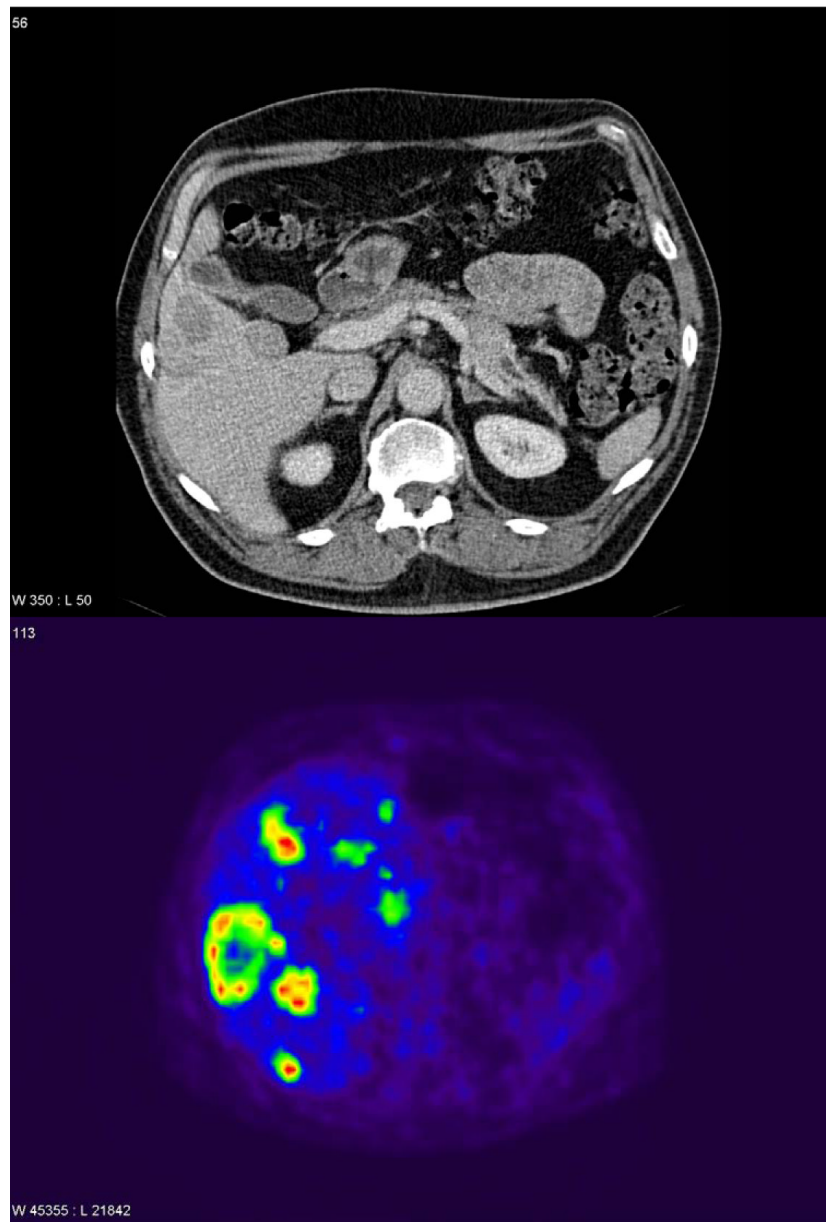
Comparison of the extent of liver metastases in a patient with a malignant PET on CT scanning (top panel) and positron emission tomographic scanning (bottom panel). This patient with a malignant PET had a few liver metastases seen on CT scanning (top) and SRS (not shown) but much more extensive disease on positron emission tomographic scanning with ^{11}C -5-HTP demonstrating its greater sensitivity. (Images kindly provided by Prof. Anders Sundin, Department of Radiology, Uppsala University Hospital, Uppsala, Sweden).
